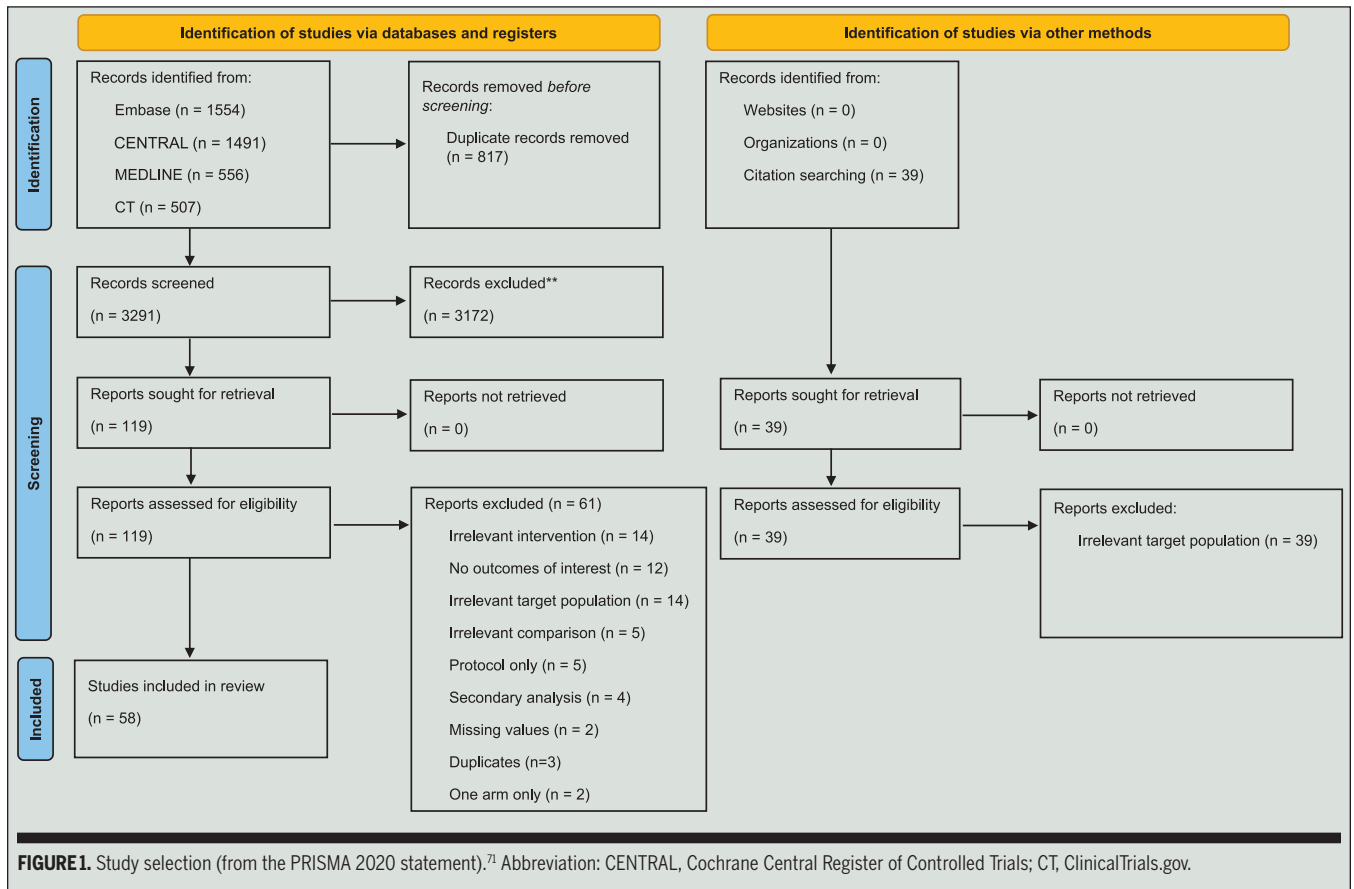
Study selection (from the PRISMA 2020 statement).⁷¹ Abbreviation: CENTRAL, Cochrane Central Register of Controlled Trials; CT, ClinicalTrials.gov.
